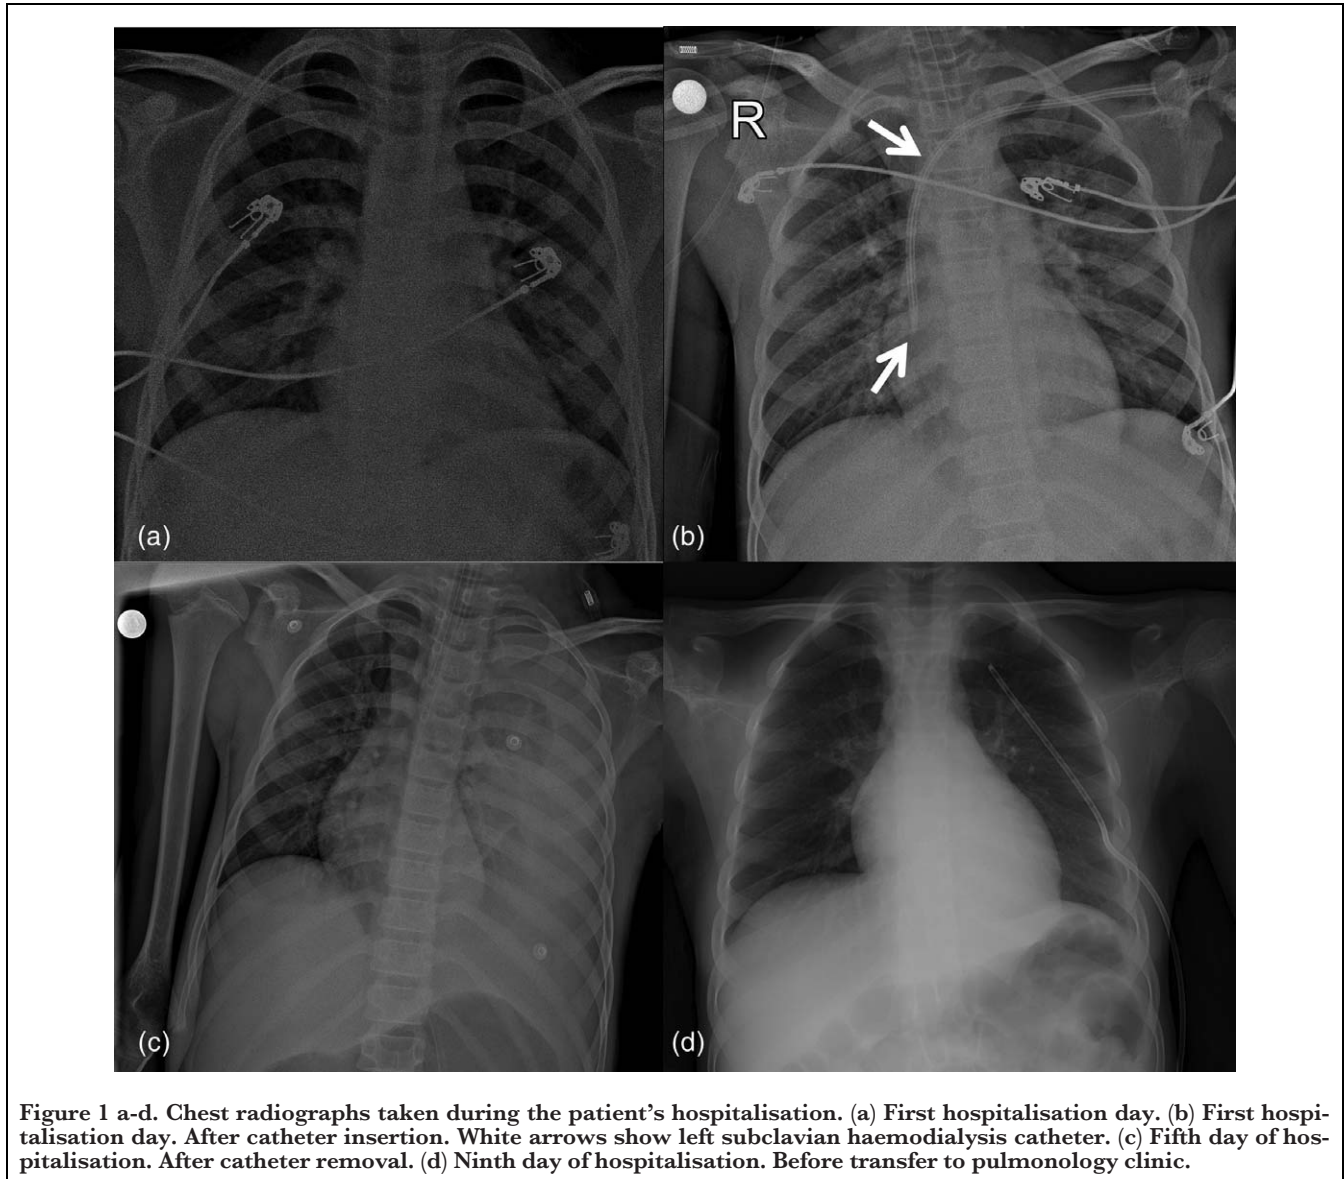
a-d. Chest radiographs taken during the patient's hospitalisation. (a) First hospitalisation day. (b) First hospitalisation day. After catheter insertion. White arrows show left subclavian haemodialysis catheter. (c) Fifth day of hospitalisation. After catheter removal. (d) Ninth day of hospitalisation. Before transfer to pulmonology clinic.
